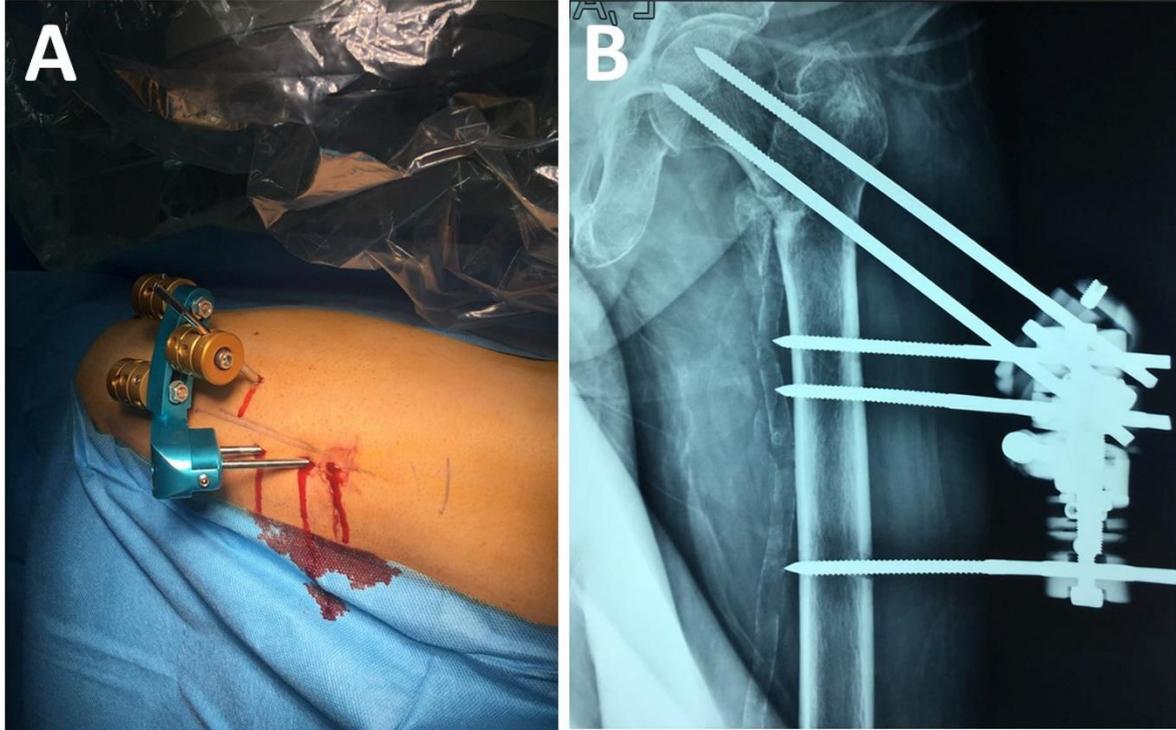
A: Dynamic Hip External Fixator after insertion in the operation room, B: post-operation anteroposterior radiograph of fixed and compressed intertrochanteric fracture
